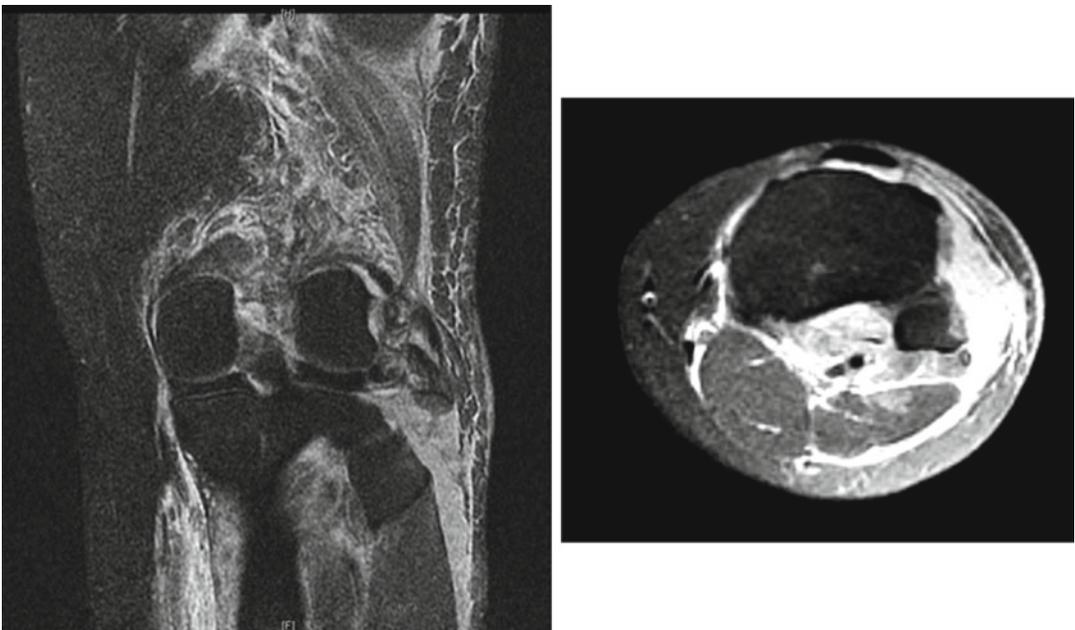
Coronal PD FS (*left*) and axial PD FS (*right*) MRI images of the same patient confirming the fibula head avulsion fracture
